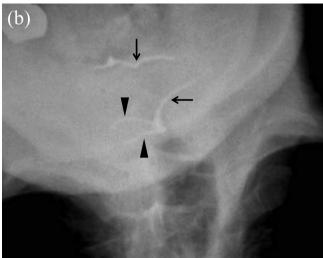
Chest X-ray (a) and enlarged image of the cervical region (b) show the clasps of the impacted denture (arrows). The end of the lower clasp (arrowheads) seems to be bifurcated toward the right side.
